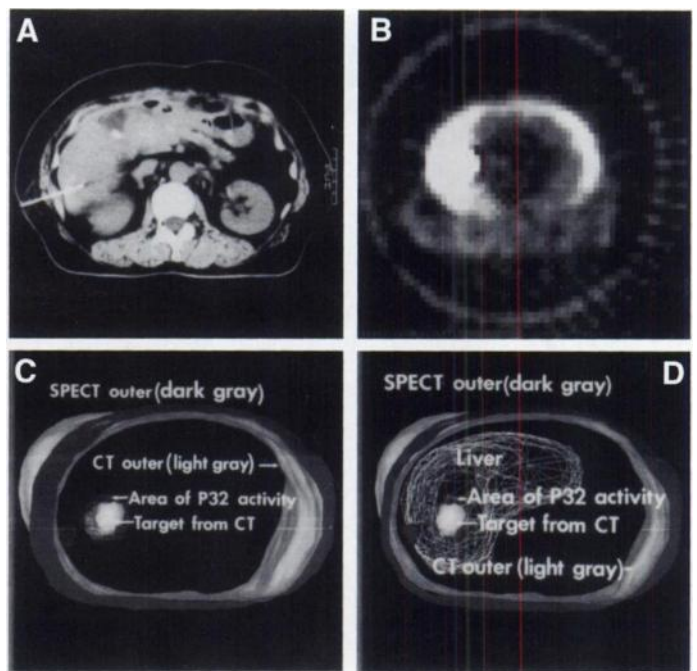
(A) Transverse CT image of the abdominal area of a patient with liver disease, where the area of abnormality and the position of needle is shown. (B) SPECT transverse image of the same patient after ^{32}P injection. (C) Three-dimensional co-registration between CT (light gray) and SPECT (dark gray) outer surfaces. The target from the CT slices (solid object) also is shown co-registered with the ^{32}P area of high activity (lines around the target) from SPECT data. (D) Three-dimensional co-registration of all structures. Liver is shown as lines for visibility of target objects.
